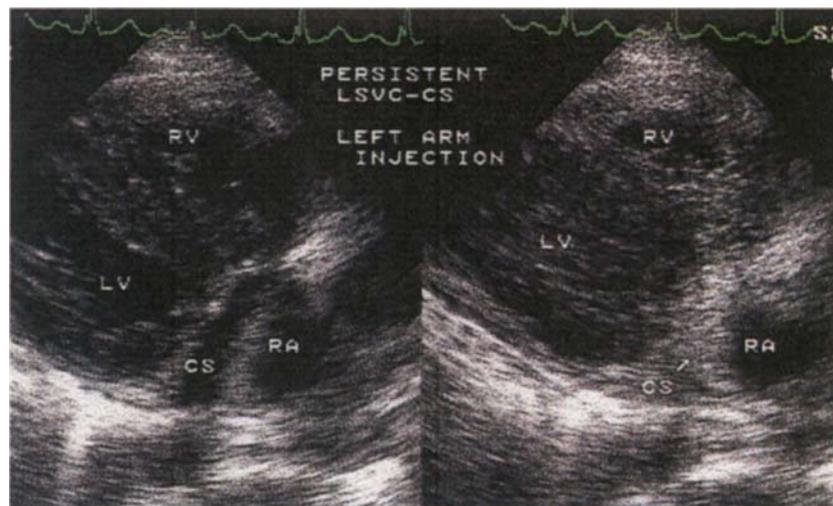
Parasternal right ventricular inflow view. A baseline image is on the left. This time peripheral saline contrast injection is performed via the left antecubital vein. The coronary sinus was seen to opacify first, followed by the right heart. RA = right atrium; RV = right ventricle; LV = left ventricle; CS = coronary sinus.
